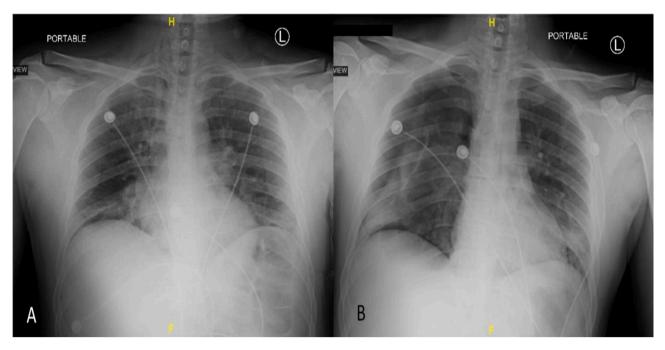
A: Chest x-ray at initial presentation showing hazy bibasilar opacities with increased interstitial lung markings suggestive of viral pneumonia Fig. 1B: Chest x-ray at follow up showing moderate right sided pneumothorax
